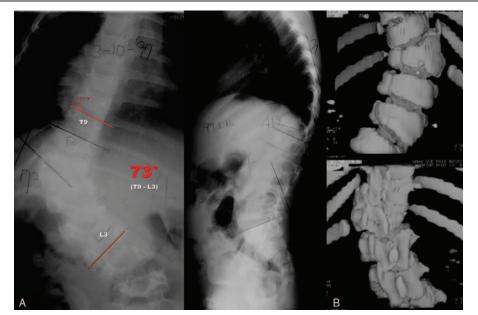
(A) Radiographs taken before the initial surgery showing a congenital hemivertebra at T12 with 73° of left thoraco-lumbar scoliosis and segmental kyphosis of 40°. (B) 3D reconstruction computed tomography scan before surgery.
